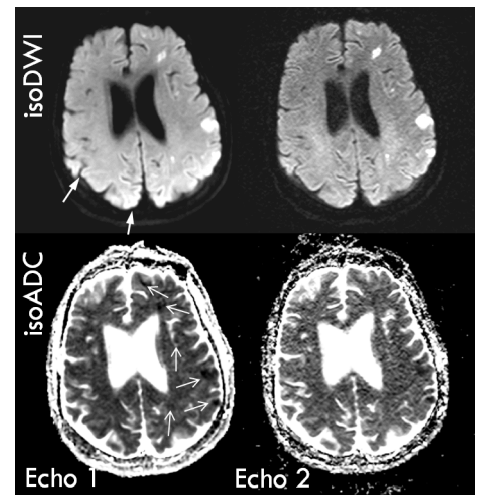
Dual echo DWI and ADC images of a 66yr old embolic stroke patient.
